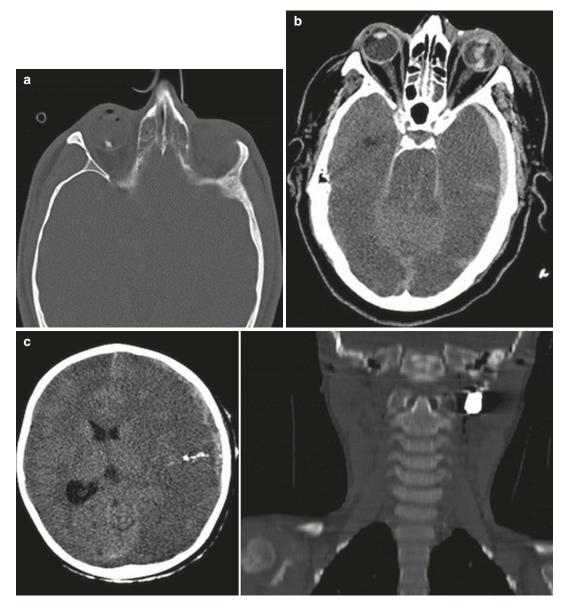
(a) Axial CT image demonstrating shrapnel in the right globe with subsequent collapse and subcutaneous emphysema. (b) Axial CT image demonstrating a left retinal hemorrhage. (c) The image on the left is a noncontrast axial CT slice that demonstrates hypoattenuation of the left
